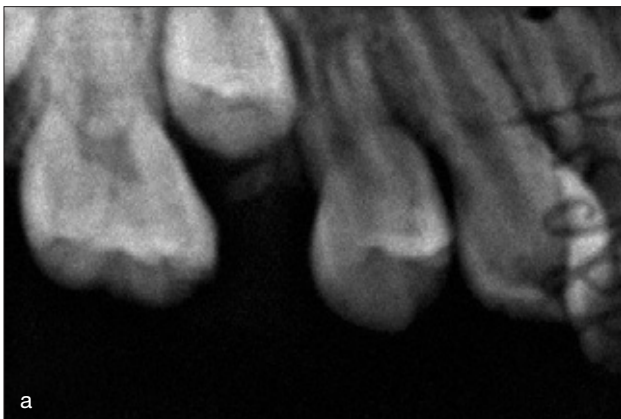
Radiographic examinations showed no destruction of bone in the maxilla: (a) periapical radiograph; (b to d) cone-beam computerised tomography.
